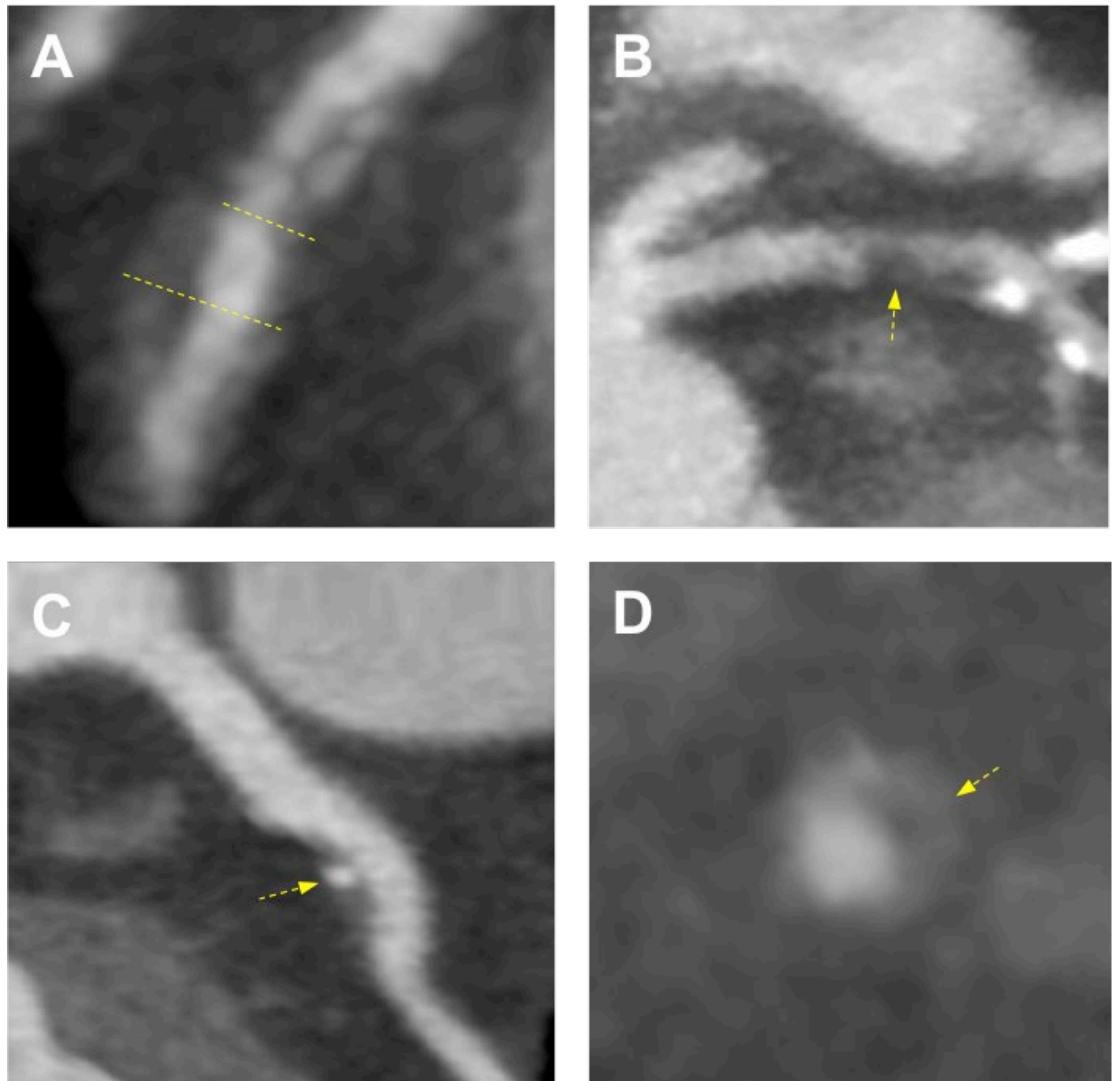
Coronary plaque characteristics identified on computed tomography coronary angiography.
